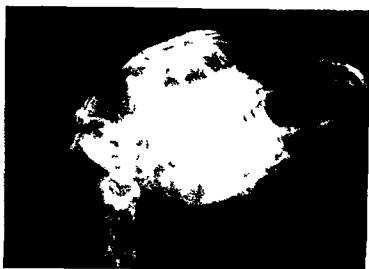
Tête de lapin radiographiée à 160 kV sur couple film industriel+écrans de plomb de 0.02 mm
